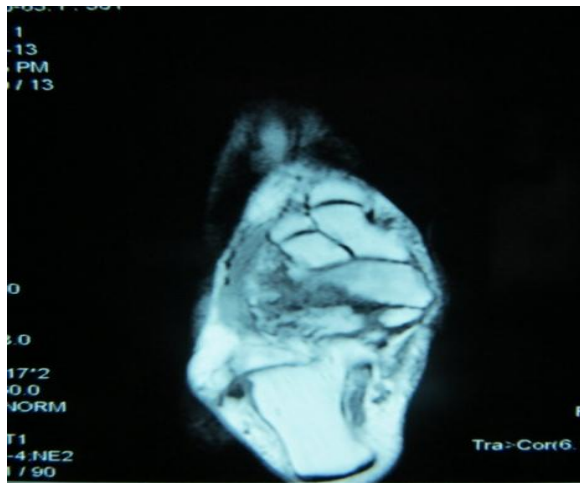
MRI of the foot showing characteristic lateral column Collapse.
